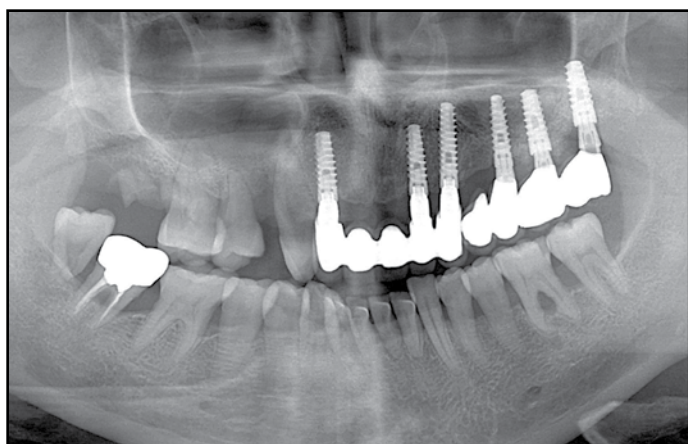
A plain radiograph after 1 year in function. Note sinus augmentation with CGF alone.
